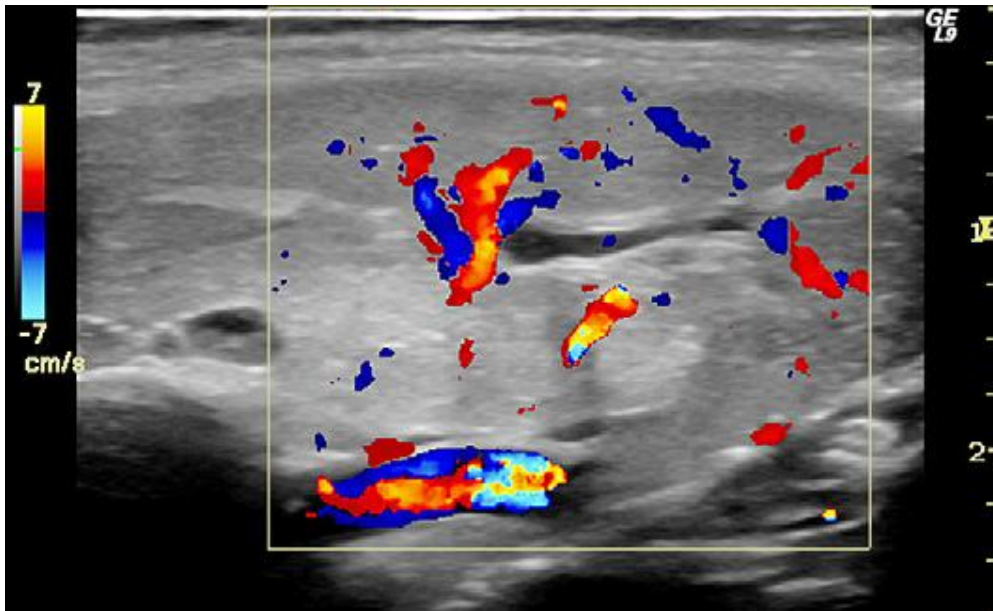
Longitudinal ultrasound of parotid gland. Color Doppler reveals hyperemia. (Philips Katz et al.)
